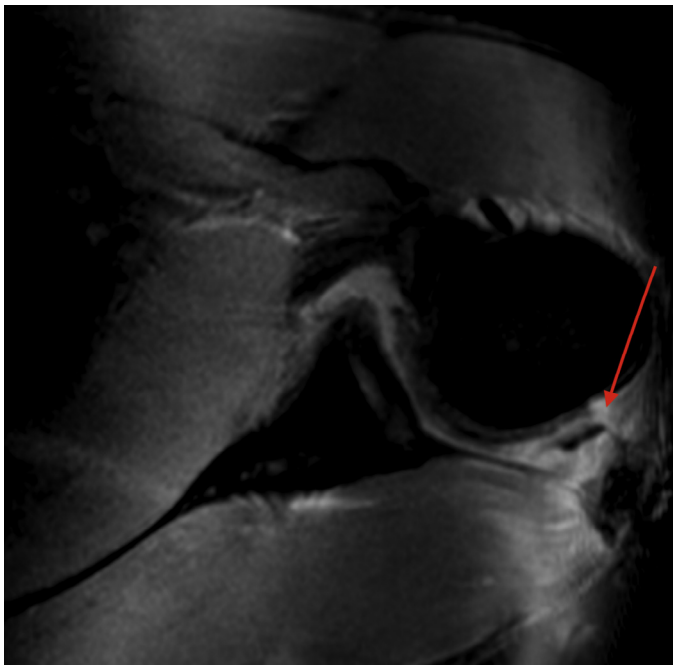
Axial magnetic resonance imaging study with the arrow pointing to the posterior humeral avulsion of the glenohumeral ligaments avulsion.
